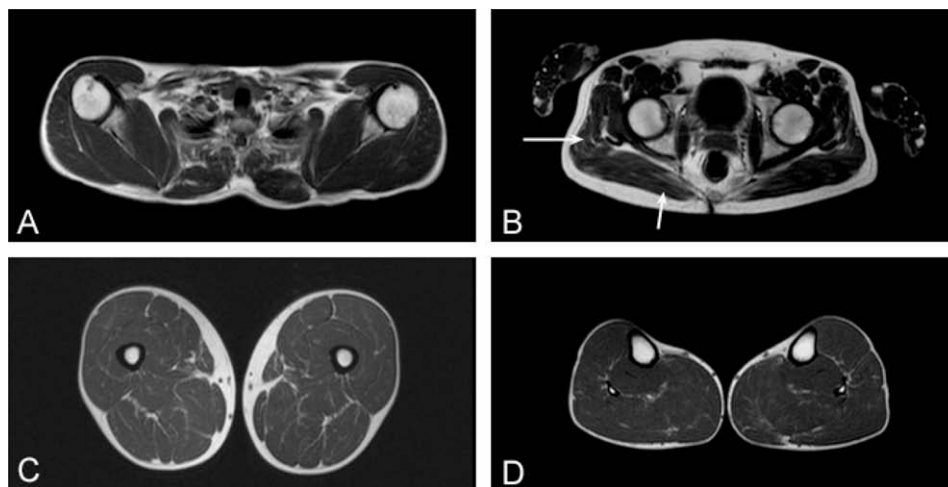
MRI images of the muscles in patient A1. MRI axial T1-weighted images of the muscles in patient A1 at age 46 shows at the level of (A) the shoulder: normal volume and signal intensity of the muscles, (B) the hip joint: minimal fatty changes in the gluteal muscles (arrows), (C) upper leg: normal volume and signal intensity of the muscles and (D) lower leg: normal volume and signal intensity of the muscles.
